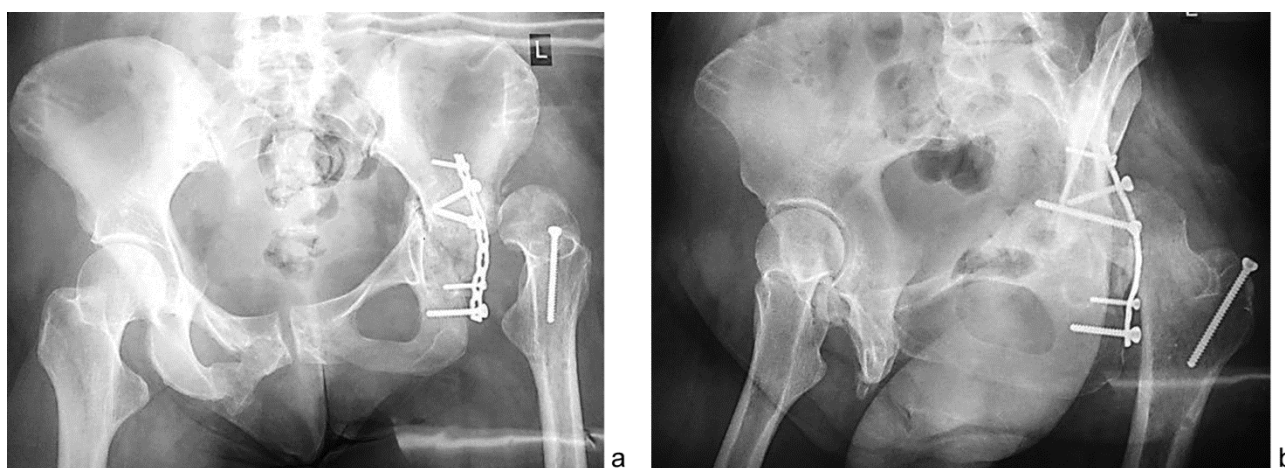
Preoperative radiographs of pelvis and the hip joints of a 32-year-old female patient T. showing the condition after surgical treatment, deformity of the left acetabulum plated, high standing femoral head on the left side, greater trochanter fixed with a screw, distorted pelvic ring and lower consolidated fracture of the pubic rami on the right: a – anteroposterior view; b – lateral projection (X-rays taken at RISC “RTO” prior to the treatment)
